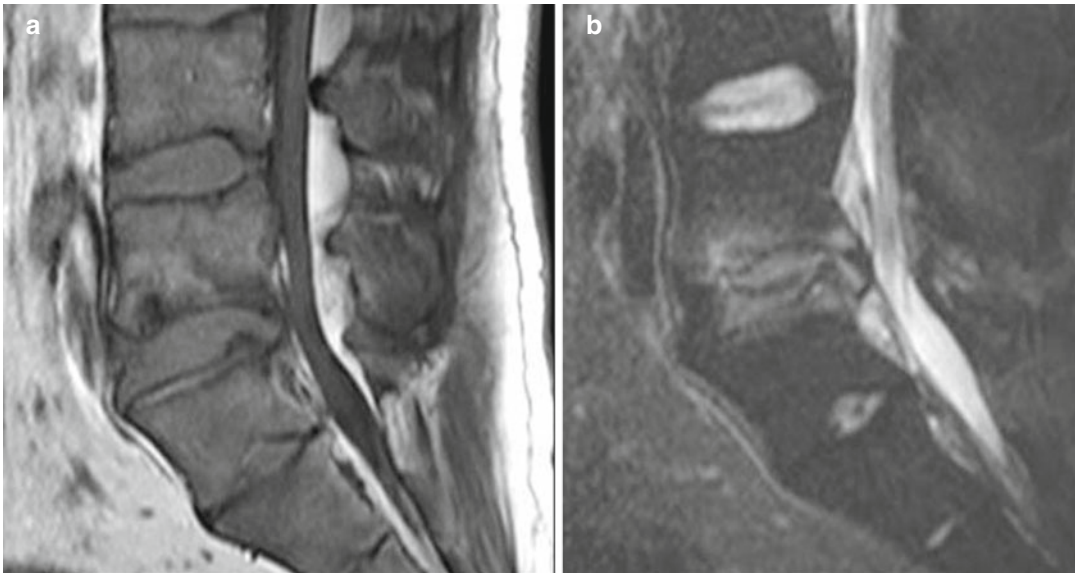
Distal lumbar spine on sagittal plane with T1-weighted (a) and FS T2-weighted (b) images. There are irregularities at the end-plates of L4 and L5 vertebrae
